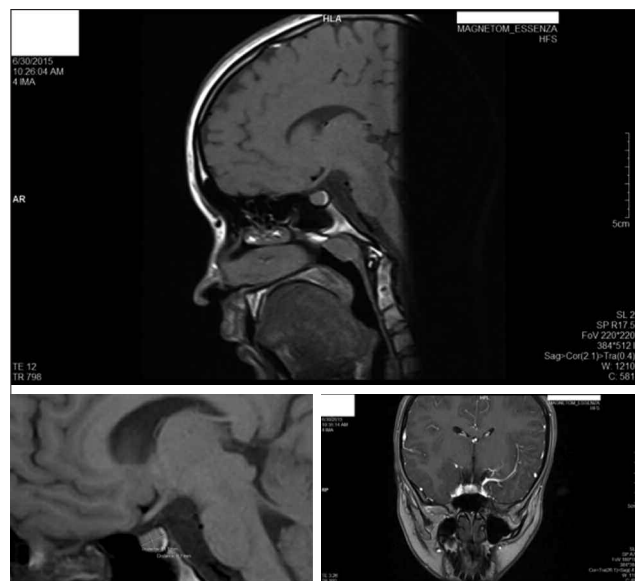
Brain MRI after 10 months of antipsychotic treatment.
